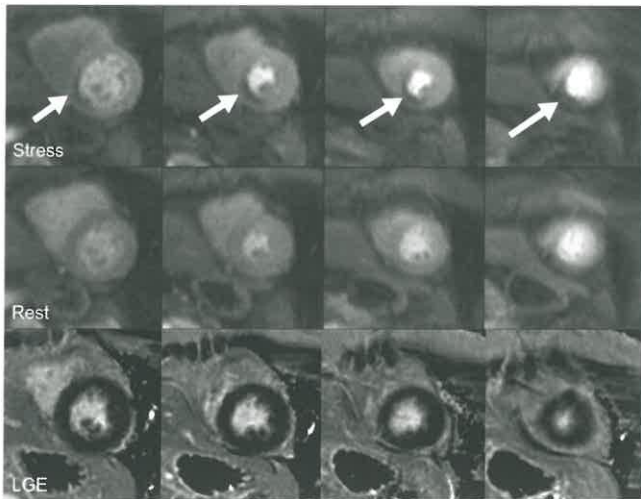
Cardiac MRI Stress Test. Stress imaging (first row) shows hypoperfusion of the inferior segments from the base to the apex (*white arrows*) which resolves on rest imaging (middle row). Delayed-enhancement imaging demonstrates no evidence of infarct. Subsequent cardiac catheterization showed a severe PDA stenosis requiring stent placement.
